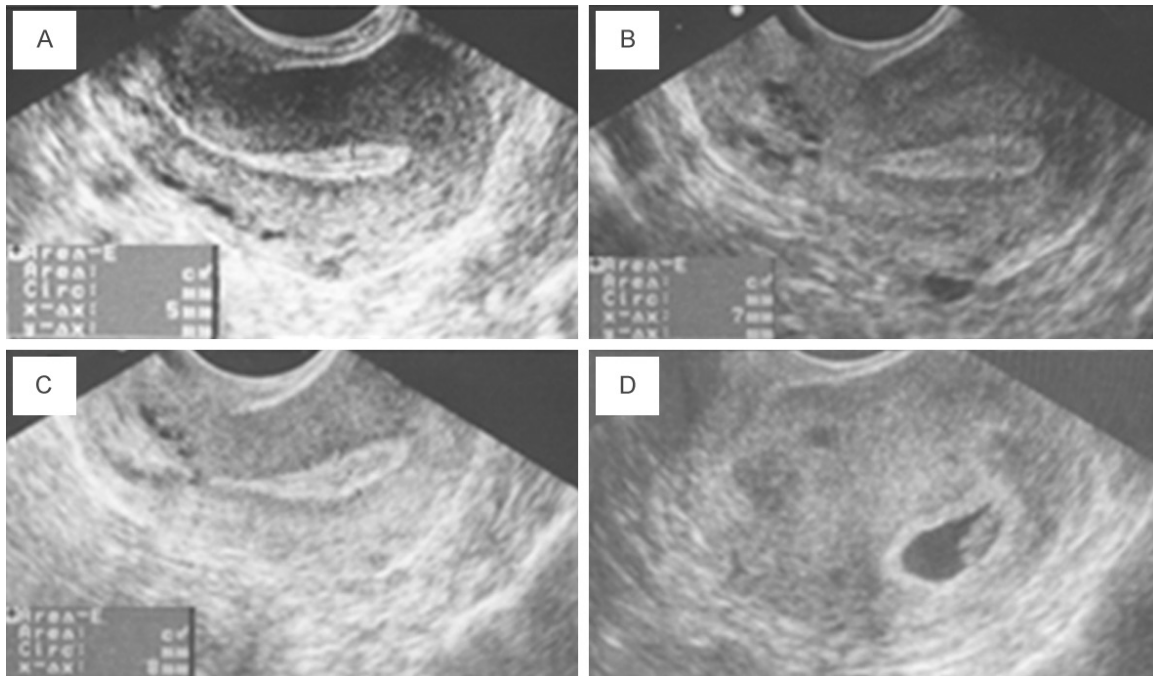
Ultrasonography in patient 1. A. Quite thin endometrium (only 5 mm) on the day of progesterone administration in traditional treatment. B. Remarkable improvement in endometrial thickness after first infusion of PRP (7 mm on day 5 before progesterone administration). C. After second infusion of PRP, the endometrial thickness reached near 8 mm on day 2 before progesterone administration. D. An intrauterine gestational sac was confirmed by transvaginal ultrasonography at approximately 6 weeks.
